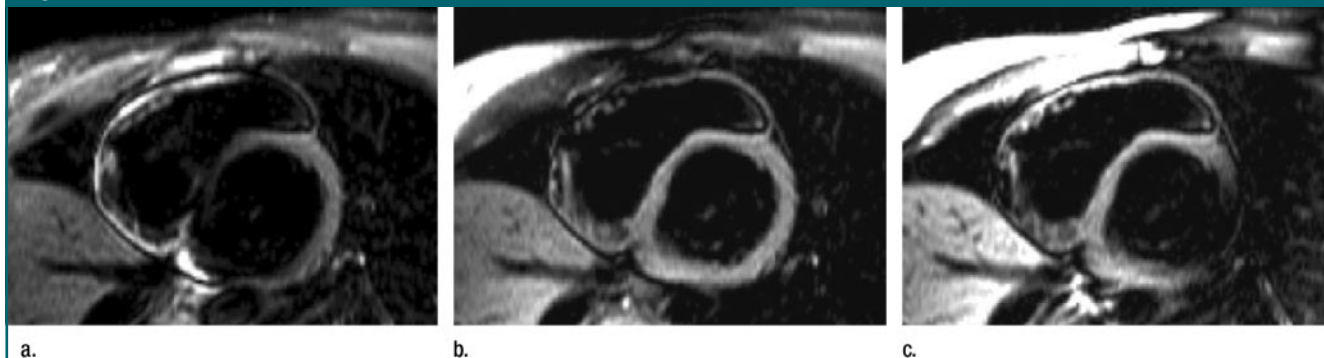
(a–c) Dark-blood T2-weighted short tau inversion-recovery turbo spin-echo MR images of basal short-axis plane in a healthy volunteer, with and without section tracking. (a) Untracked conventional, (b) LV-tracked, and (c) RV-tracked acquisitions. In b and c, section-selective preparation pulses (dark-blood and short tau inversion-recovery) are positioned to take into account motion of ventricle of interest between preparation and imaging phases. (Adapted and reprinted, with permission, from reference 84.)
